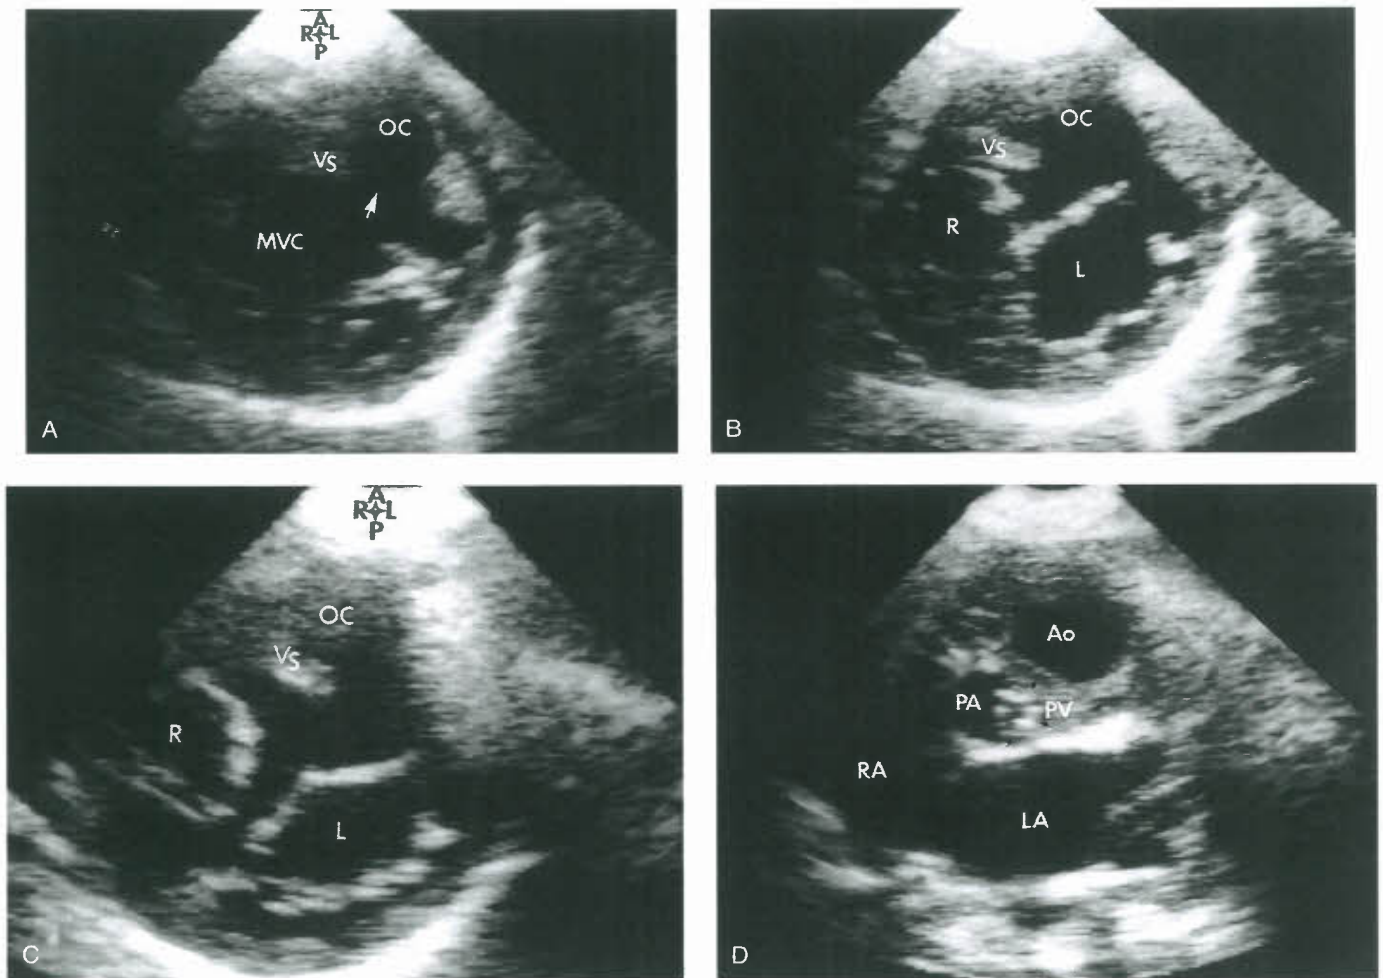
Progressive parasternal short-axis scans from apex (A) to base (D) in a patient with DILV with left-anterior subaortic right ventricle. There is a large VSD (white arrow) from the main ventricular chamber (MVC) of the left ventricular morphology into the hypoplastic outlet chamber (OC) of right ventricular morphology. The left (L) AV valve straddles into the right ventricular chamber through the VSD. There is pulmonary valve (PV) stenosis with thickened leaflets (black arrows). Ao, aorta; LA, left atrium; PA, pulmonary artery; R, right atrioventricular valve; RA, right atrium; VS, ventricular septum.
